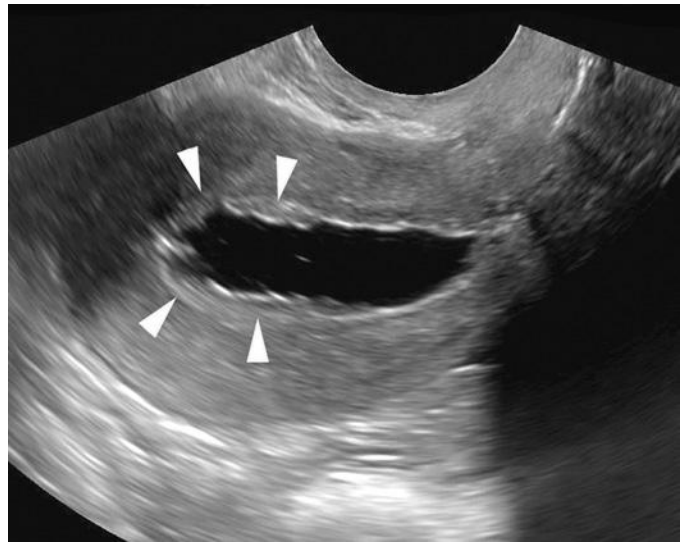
A 32-year-old woman with bleeding and cramping. Longitudinal transvaginal sonography of the uterus obtained during saline infusion sonohysterogram demonstrates diffuse thickening of the endometrium (arrowheads) consistent with endometrial hyperplasia.
